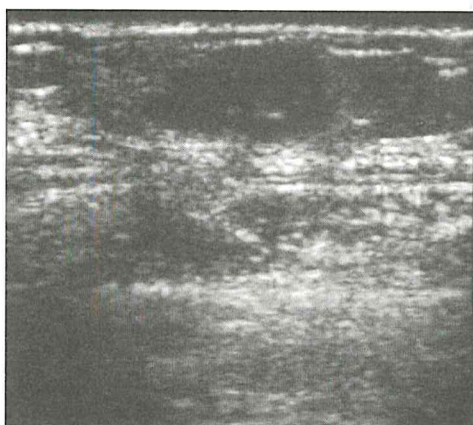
Sonography shows a circumscribed, lobular hypoechoic mass with small internal cystic spaces.
